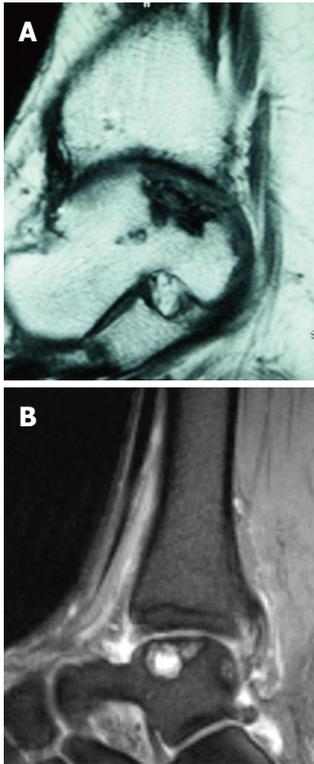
Sagittal T1 and T2-weighted magnetic resonance imaging scan. A: Sagittal T1-weighted magnetic resonance imaging scan demonstrating deep osteochondral defect of the posterior aspect of the talus; B: Sagittal T2-weighted magnetic resonance imaging scan showing the several cystic lesions of the talus in addition to an osteochondral defect.
